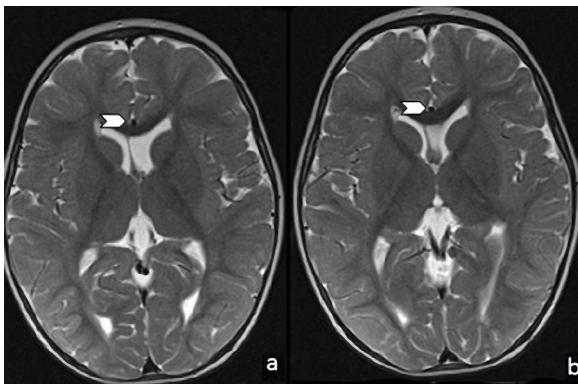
Axial T2 weighted MRI of the brain showing the septum pellucidum off-midline, favoring the right frontal horn. There appears to be a remnant of the left septal leaflet extending from the fornix to the wall of the ventricle. There is a single, prominent anterior cerebral artery (arrowhead).
